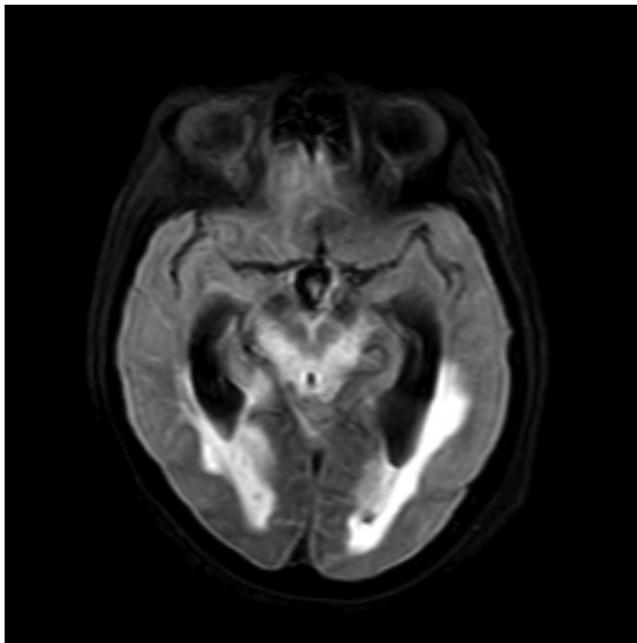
MRI brain T2W FLAIR showing marked edema throughout the brainstem. Abbreviations: FLAIR, fluid attenuated inversion recovery; MRI, magnetic resonance imaging.
